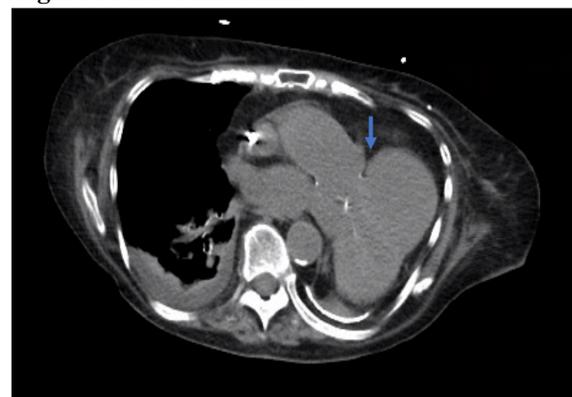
CT Chest Coronal
